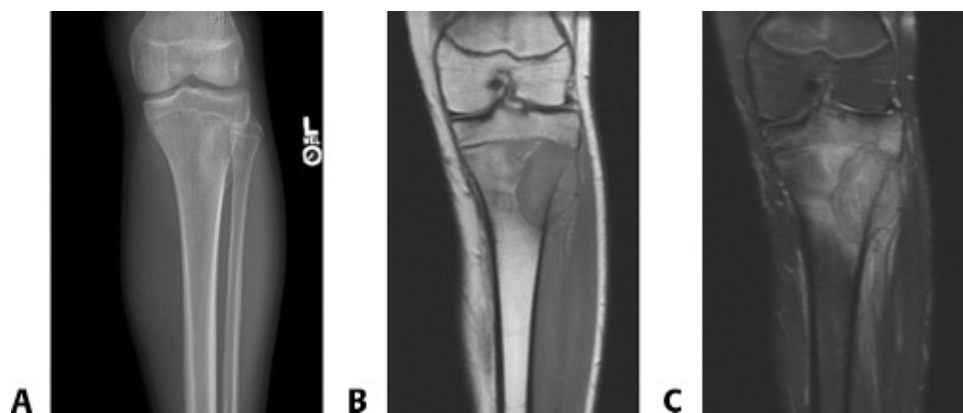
• A. AP radiograph, (B) coronal T1 MRI, and (C) coronal T2 MRI of a primary bone tumor of the lateral proximal tibia.
